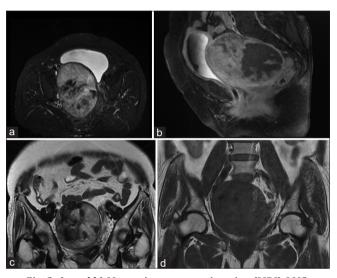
(a and b) Magnetic resonance imaging (MRI)-LMS frequently manifests as a large, solitary, infiltrating myometrial mass with ill-defined margins and heterogeneous SI. The heterogeneity reflects focal areas of hemorrhage, necrosis. (c and d) MRI abdomen and pelvis were done to look for myometrial invasion and reported as a degenerated Fibroid (11.8×9.4×9.64 cm) in the posterolateral wall of the uterus noted with endometrial thickening of 4.7 mm in the endometrial cavity and the margin appears smooth and regular in shape
